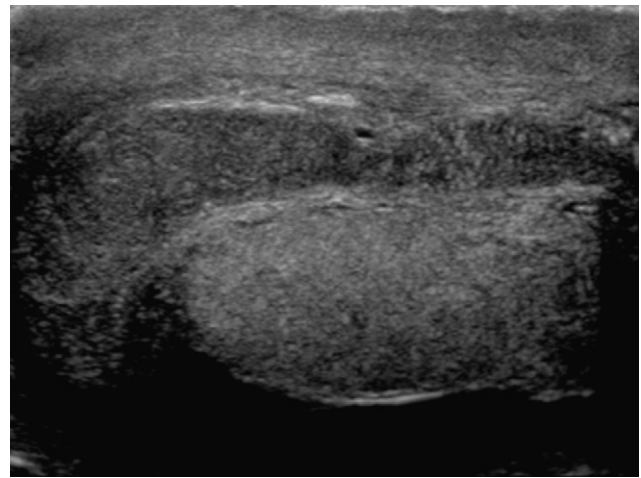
B-mode sonogram view along the axis of the right epididymis, passing through the tail.
